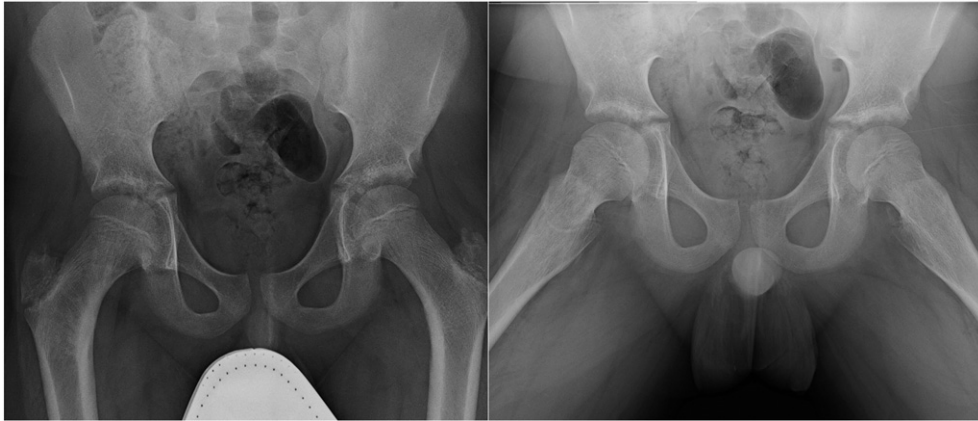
Anterior-posterior and frog-leg hip radiographs.
